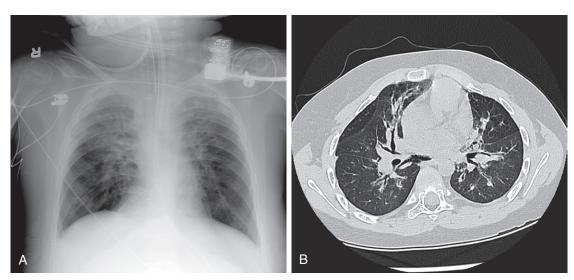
Bronchiolitis obliterans. A, Posteroanterior chest radiograph of 17-year-old with end-stage obliterative bronchiolitis as a complication of bone marrow transplantation for acute myelogenous leukemia. Film demonstrates increased interstitial and airway markings. B, CT of same patient demonstrates bronchiectatic changes. (Courtesy Beverly Newman, MD, Pittsburgh, Pa.)
